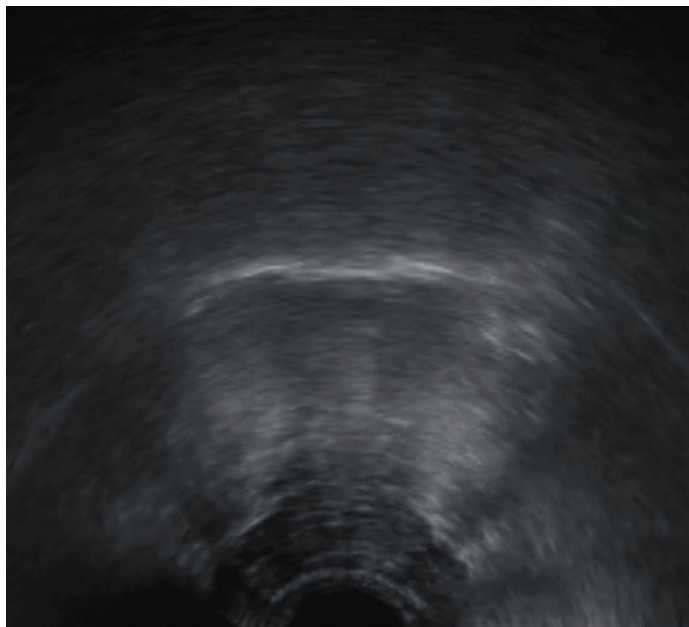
The transverse view of the tongue obtained in ultrasound examination
